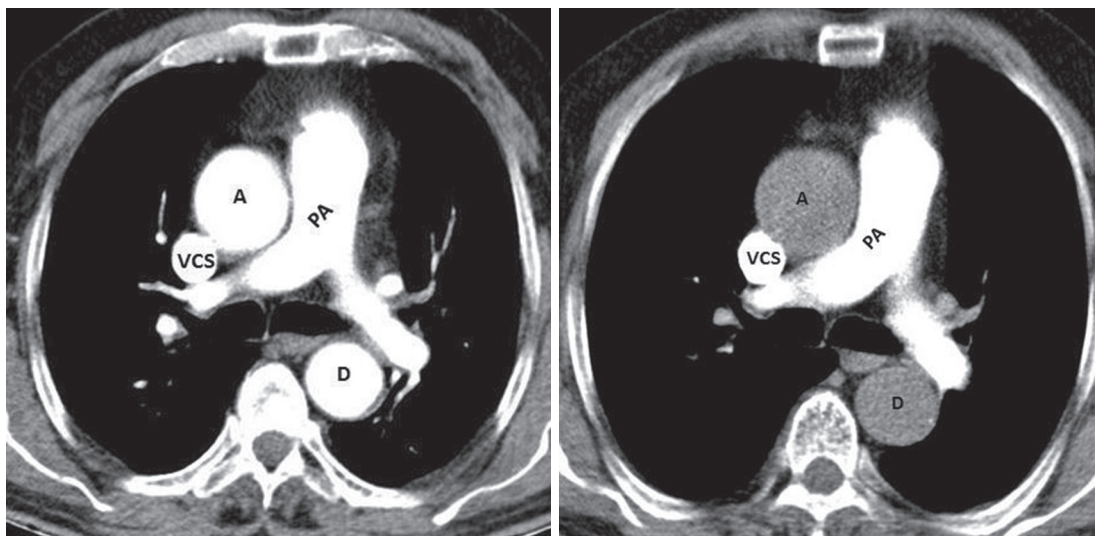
A standard axial image from a computed tomography scan demonstrating an ascending aortic aneurysm. A: Ascending aorta; D: Descending aorta; PA: Pulmonary artery; VCS: Vena cava superior.
